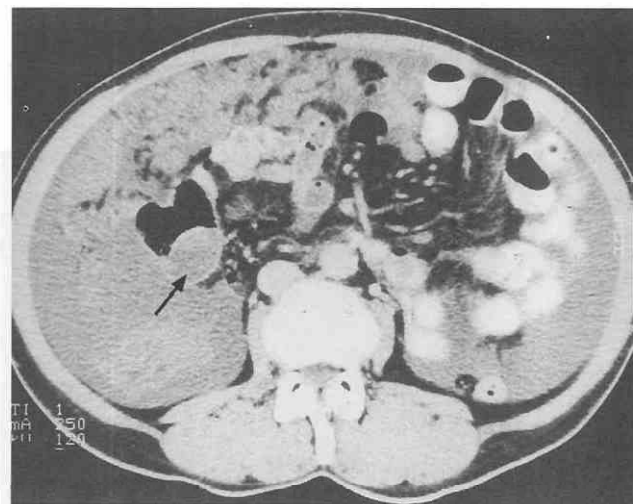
Mucinous cystadenocarcinoma of the appendix with pseudomyxoma peritonei. CT scan shows nodular omental infiltration and a large amount of ascites. A cystic mass (arrow) is seen in the pericecal region.
